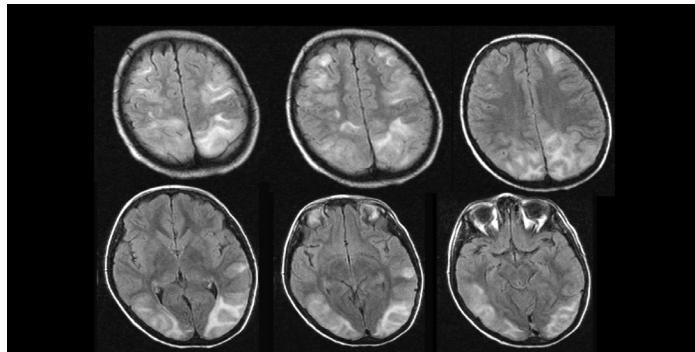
Brain MRI (FLAIR) showing an increase of signal in both hemispheres, predominantly in posterior zones.
